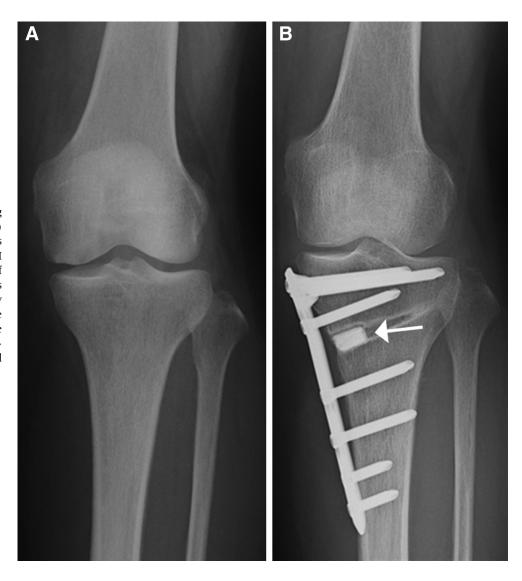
Anteroposterior standing radiographs of the left knee. (A) The preoperative x-ray shows Kellgren-Laurence grade I osteoarthritis with 87° of mMPTA. (B) The mMPTA was corrected to 92° on the x-ray one month after surgery. The white arrow indicates the bone substitutes. mMPTA, mechanical medial proximal tibial angle. ¹³
